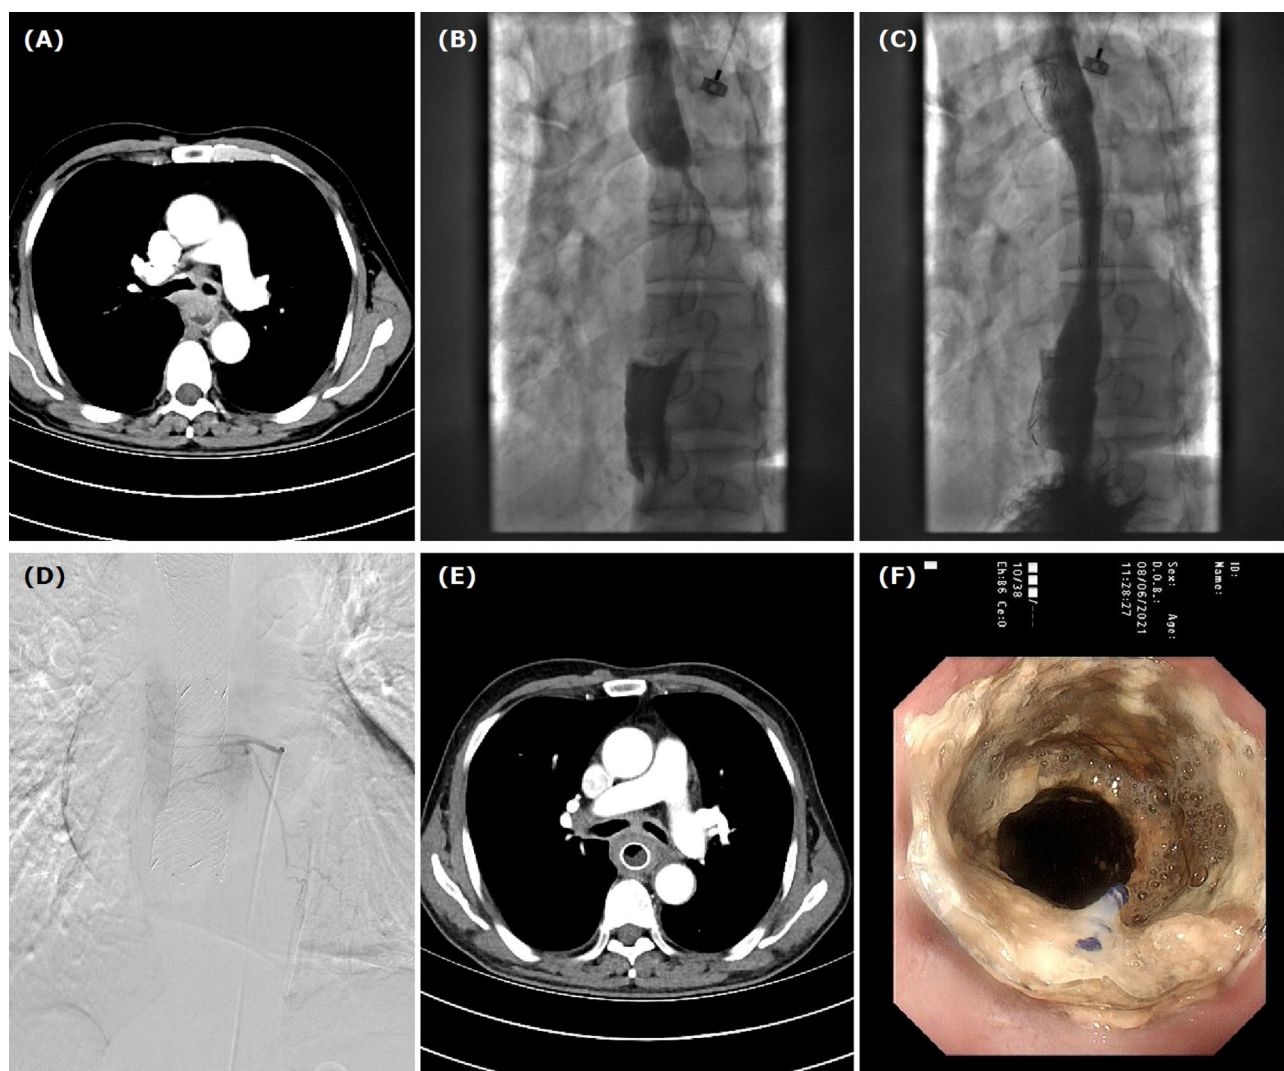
Images of a 65-year-old male with esophageal cancer in middle and lower esophagus. (A) Chest CT scan shows an obvious thickening and apparently enhanced mass with invasion into tracheal wall. (B-C) Severe stenosis was seen in the middle and lower segments of the esophagus, and an 18*120 mm esophageal stent was inserted. (D) The proper esophageal artery is super-selectively catheterized and embolized using oxaliplatin loading-CB. (E) Chest CT scan shows that the lesion has significantly reduced and the arterial phase enhancement is not apparent after 6 weeks. (F) Endoscopic examination was performed after about 7 months
